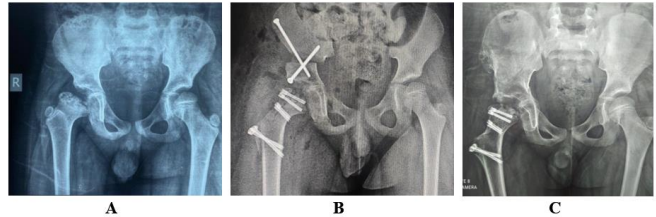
(A) preoperative radiographs of 12-year-old boy with show right coxa magna, coxa breva, overriding trochanter. (B) Immediate postoperative radiograph show FHRO, RNL and simultaneous a triple osteotomy. (C) after removal of iliac screws 24-months after the index surgery.
